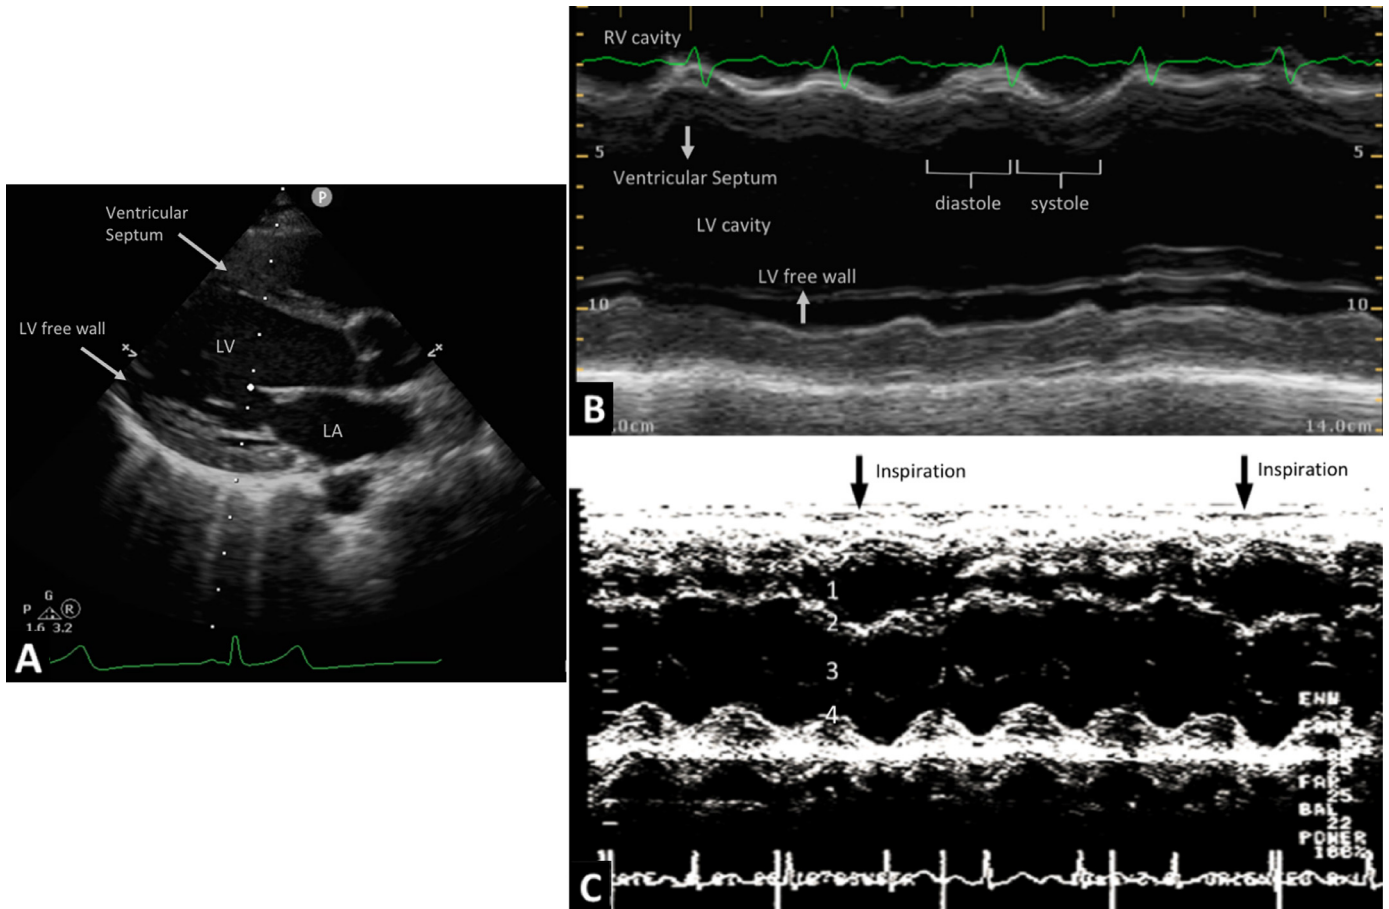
Motion of the ventricular septum by transthoracic echocardiography. (A) Two-dimensional image of parasternal long-axis view, describing the image acquisition before M-mode imaging of the ventricular septum; the M-mode line (white dotted line) is placed across the right ventricular outflow tract and below the tips of the anterior mitral leaflet; then, M-mode imaging can be recorded. (B) M-mode image of normal motion of the ventricular septum. From top to bottom, right ventricular cavity, ventricular septum (upper arrow), left ventricular cavity, and left ventricular free wall (lower arrow). During diastole (left bracket), the ventricular septum thins and moves rightward (toward the right ventricle); during systole (right bracket), the ventricular septum thickens and moves leftward (toward the left ventricle). (C) M-mode image of abnormal motion of the ventricular septum in a patient with severe asthma. From top to bottom, right ventricular cavity (1), ventricular septum (2), left ventricular cavity (3), and left ventricular free wall (4). During inspiration (arrows), there is leftward shift (toward the left ventricular cavity) and flattening of the ventricular septum as a major contributor to the transitory decrease in left ventricular cardiac output during inspiration (ie, pulsus paradoxus). RVOT, right ventricular outflow tract; VS, ventricular septum;
